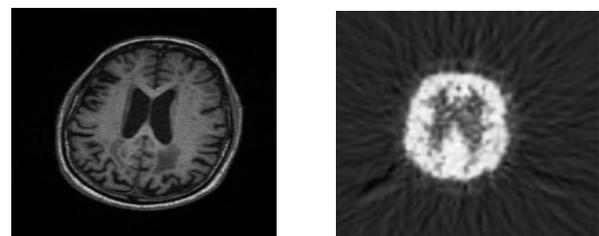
MRI and PET Scans
